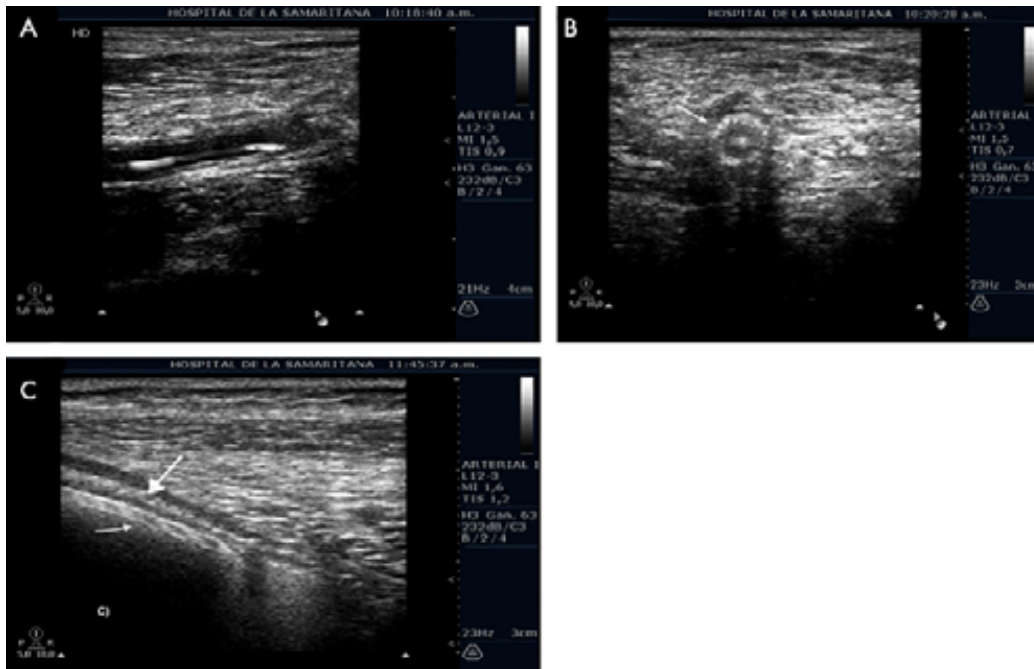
Duplex ultrasound-guided endovascular mechanical thrombectomy. A) ultrasound-guided navigation (hydrophilic guidewire) through the blocked stent; B) axial slice showing normal localization and transintimal dissection of hydrophilic guidewire; C) ultrasound-guided mechanical thrombectomy (light arrow: Rotarex® system, bold arrow: anterior aspect of the stent).
